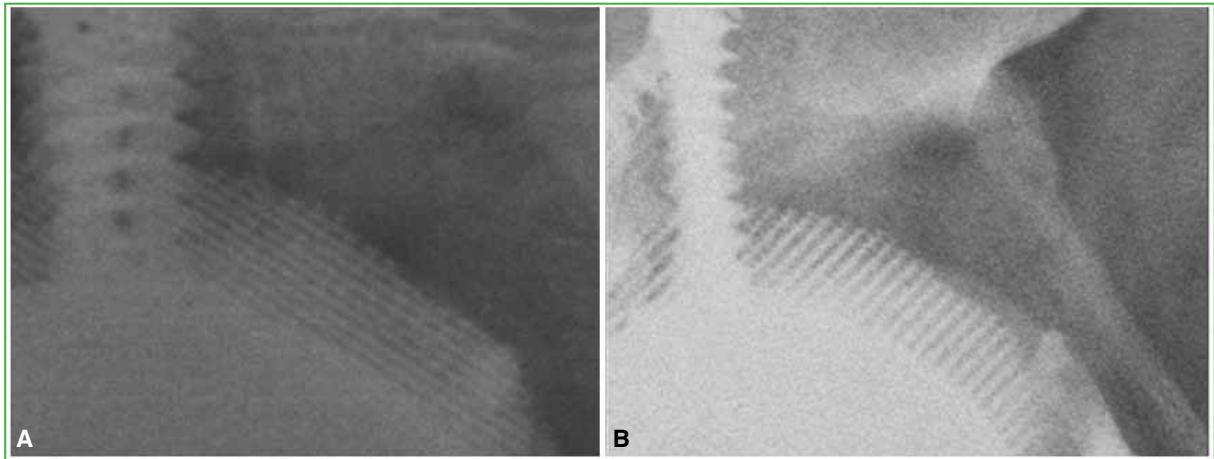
A. Magnified radiograph of the right hip, AP view, in the immediate postoperative period. The trabecular metal of the 3D implant is observed. B. Magnified radiograph of the right hip, AP view, 3 months after surgery. Signs of osseointegration are detected around the trabecular metal.
